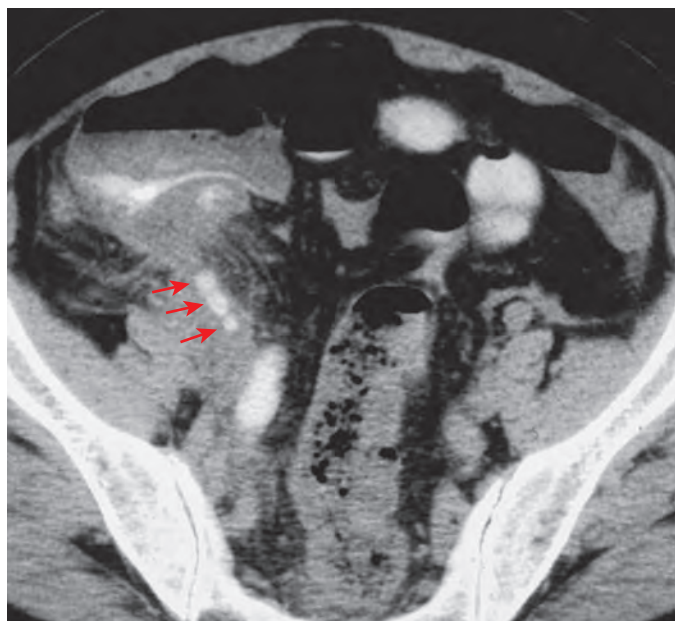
Acute appendicitis on CT. Although the appendix itself is not distinctly identified, there are three appendicoliths (arrows) present in association with right lower quadrant inflammation and pericecal thickening. This constellation of findings is diagnostic of acute appendicitis.
